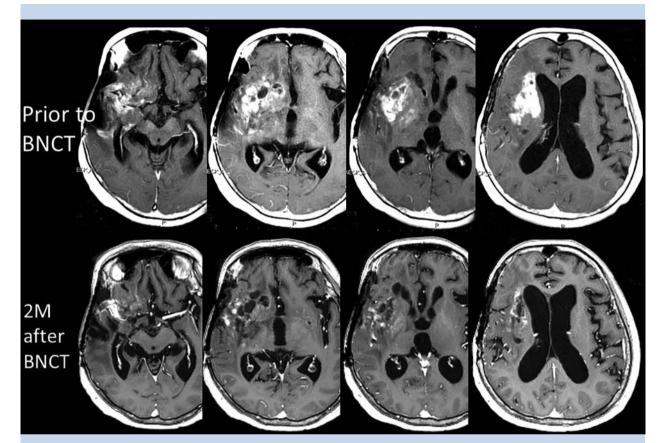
Representative MRI changes in a case of recurrent malignant glioma treated by BNCT.
